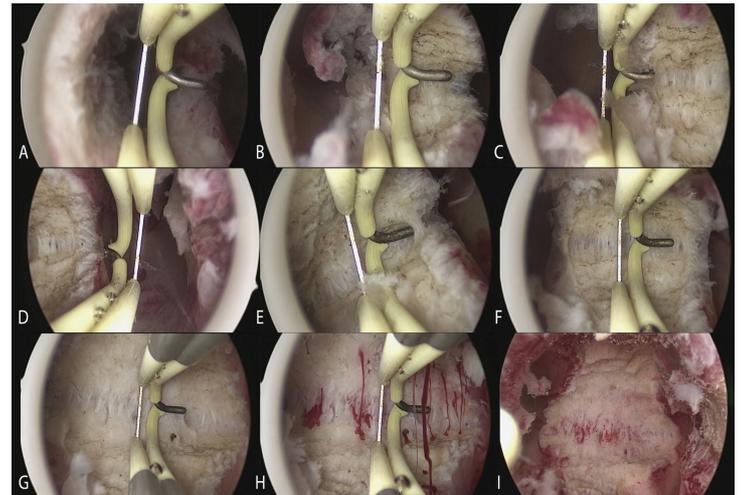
Hysteroscopic metroplasty with miniaturized instruments on a U2a uterus (partial septate uterus). The first 2.5 cm of the septum are resected using a 5F bipolar electrode (A–C) followed by the last 0.5 cm, which are incised using blunt scissors (D). (E) Use of the intrauterine palpator to measure the resected septum length to correlate with the preoperative 3D ultrasounds evaluation. (F) Final view of the uterine cavity (7).
